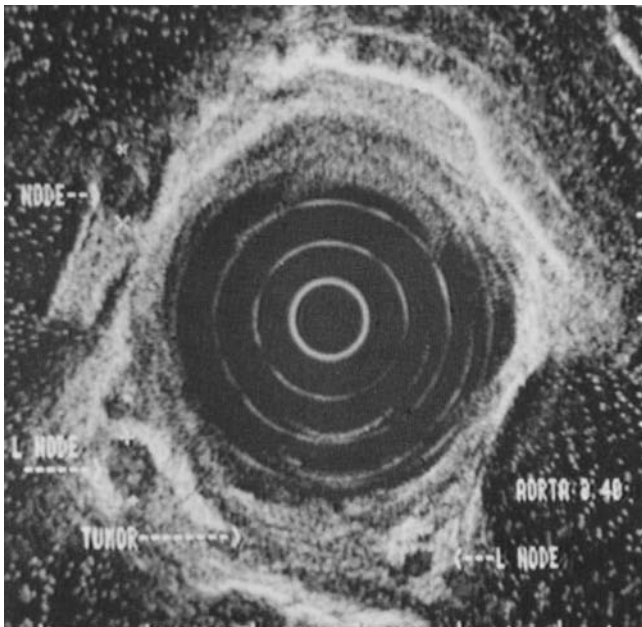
Endoesophageal ultrasound image of an adenocarcinoma of the esophagus (T3) and multiple lymph nodes suspicious for metastatic disease (N1). (Reproduced with permission from Van Dam J, Sivak MV, Catalano MF, et al. High-grade malignant stricture is predictive of esophageal tumor stage: risks of endosonographic evaluation. *Cancer*. 1993;May 15; 71(10):2910–2917.)
